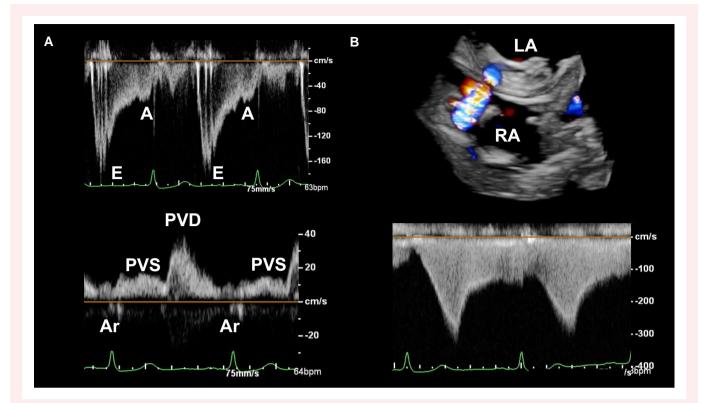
Transesophageal echocardiogram of a 79-year-old woman. Transmitral Doppler signal shows a prominent E wave of 176 cm/sec followed by rudimentary A wave of only 58 cm/sec. Pulmonary venous flow showed a significantly blunted systolic forward (PVS) flow, extremely small retrograde flow reversal (Ar) during atrial contraction, and a prominent diastolic wave (PVD) velocity (A). Three-dimensional transoesophageal echocardiography shows that a peak pressure gradient across the atrial septum was measured at 36 mmHg at end-systole (B). RA, right atrium.
